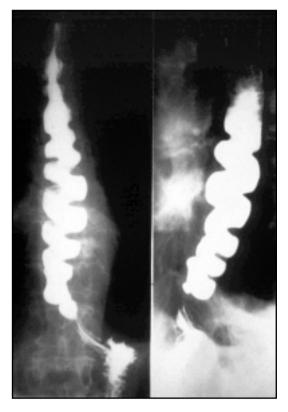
Roentgenograms taken during a barium swallow in a patient with diffuse oesophageal spasm showing the typical trapped barium in poorly sequenced peristaltic waves, producing the appearance of corkscrewing or diverticula.
